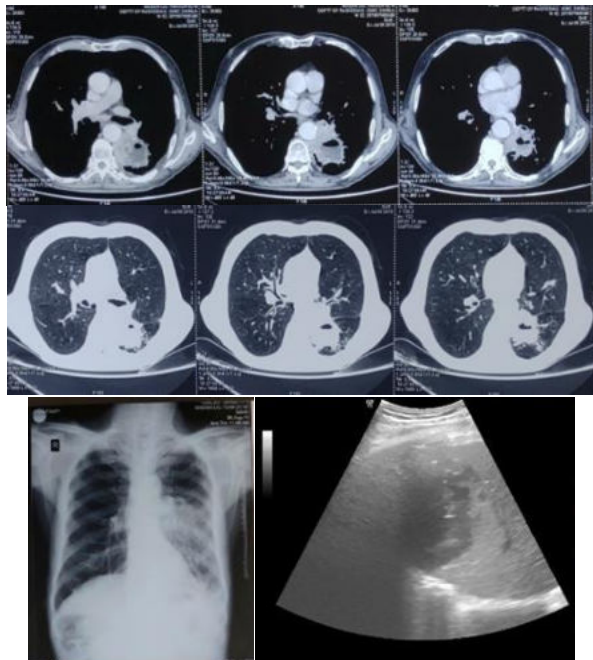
CECT thorax shows heterogeneously enhancing thick walled cavitatory lesion seen in the superior segment of LLL with spiculated margins and air fluid level with in it. Patch of consolidation with multiple nodules in medialbasal and posterobasal segments of LLL. Chest radiograph showing patch of consolidation in left mid and lower zone with mass lesion in left mid zone and sonography shows hypoechoic mass lesion with air foci in it.
